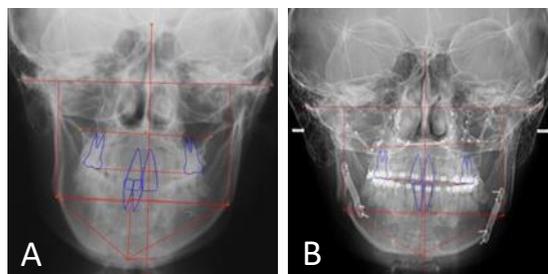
Frontal Cephalometric Radiographs: (A) Facial asymmetry before surgery, (B) Improvement of facial asymmetry after surgery
